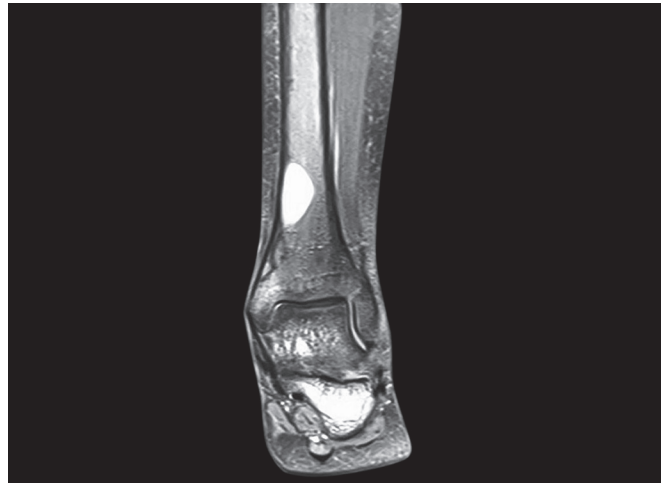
MRI foot showing lytic lesion in femur
